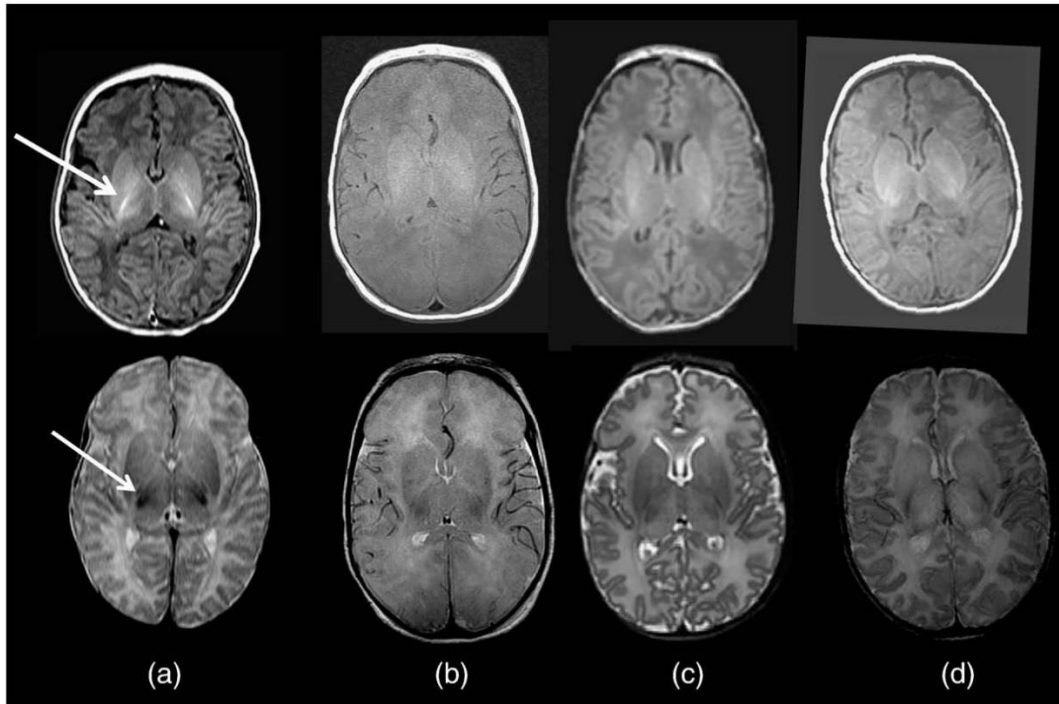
MRI images comparing the brain of a healthy term neonate with three term neonates with HIE. This image was published by Rutherford et al. (30) with the following legend: the posterior limb of the internal capsule. T1 weighted images (top row) with T2 weighted images (bottom row). (a) Normal appearances of the posterior limb of the internal capsule (arrows). (b, c, d) Abnormal appearances of paired T1 and T2 weighted sequences in three different infants with HIE.
